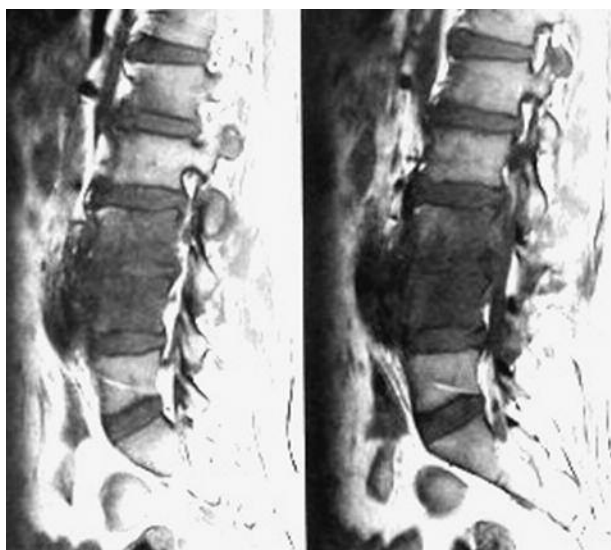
Preoperative sagittal MRI-scan of the lumbar spine. T2-weighted images showing L3-L4 spondylodiscitis.
